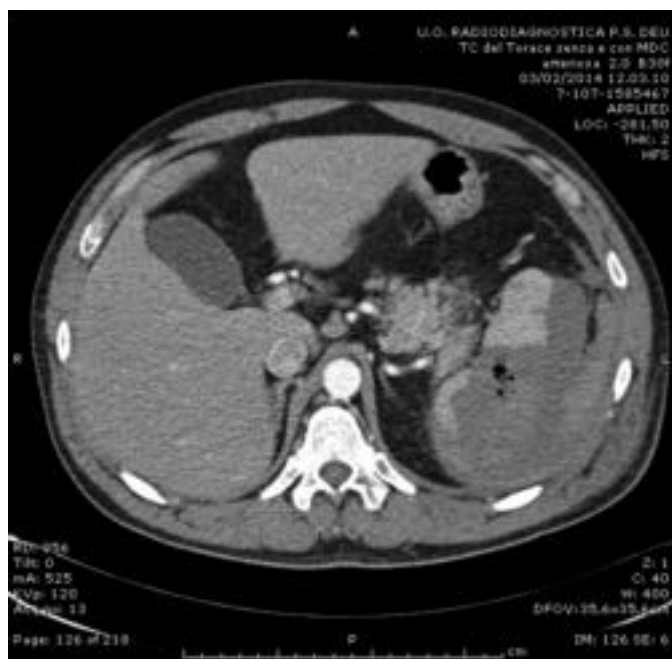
Abdomen CT after SAE: voluminous unequal effusion inside the spleen (measures 11,5cm x 6,7cm x 16cm APxLLxCC) with hyperdense signal due to blood composition and air bubbles related to a septic-inflammatory process
